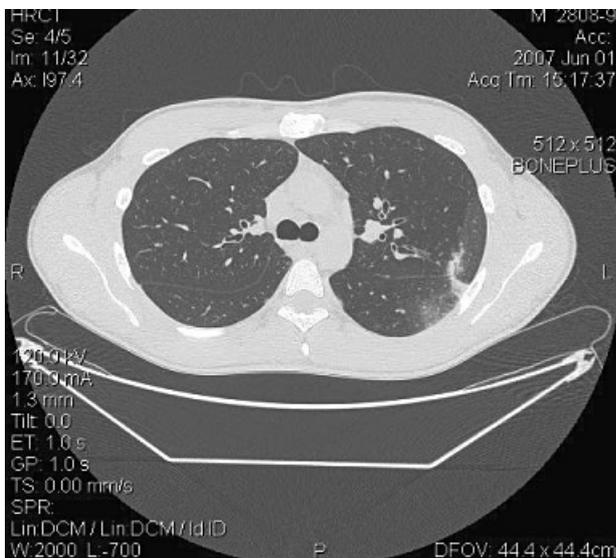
HRCT depicts ground-glass opacities in the lingula.
